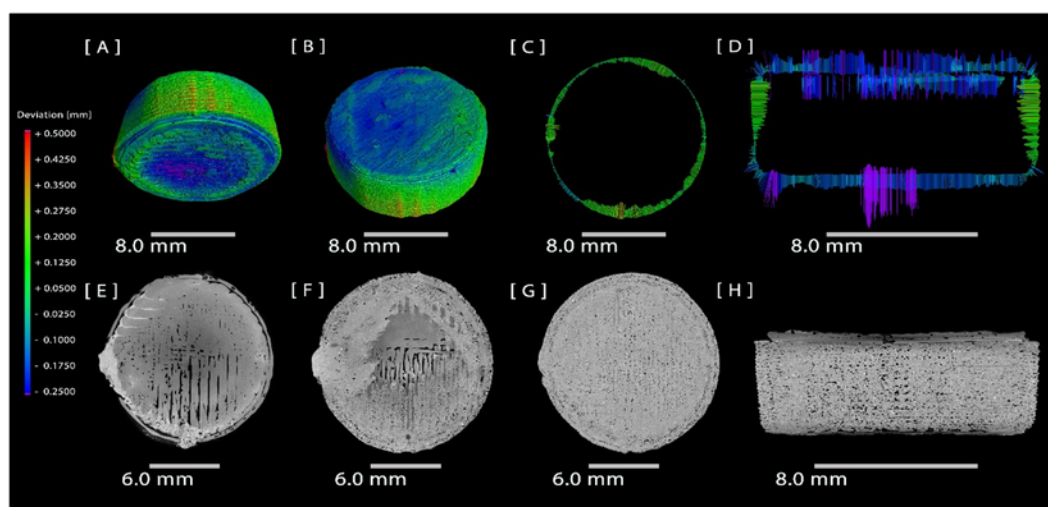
[a & b]: Combined  $\mu\text{CT}$  and deviation map volume renderings showing the deviation from the CAD design with respect to each one of the deposited layers; i.e. Eudragit® (turquoise) and PVA (khaki-brown). (For interpretation of the references to color in this figure legend, the reader is referred to the web version of this article.)
